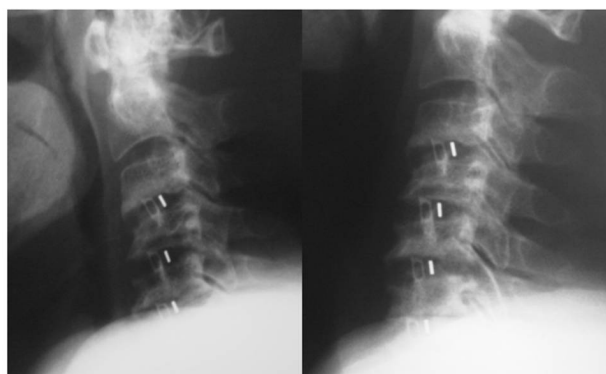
Dynamic lateral radiograph of a 76 year-old male patient with pseudarthrosis at C4-5 level at his final follow-up examinations. There was no instability and pain so the asymptomatic patient did not undergo a redo surgery.
